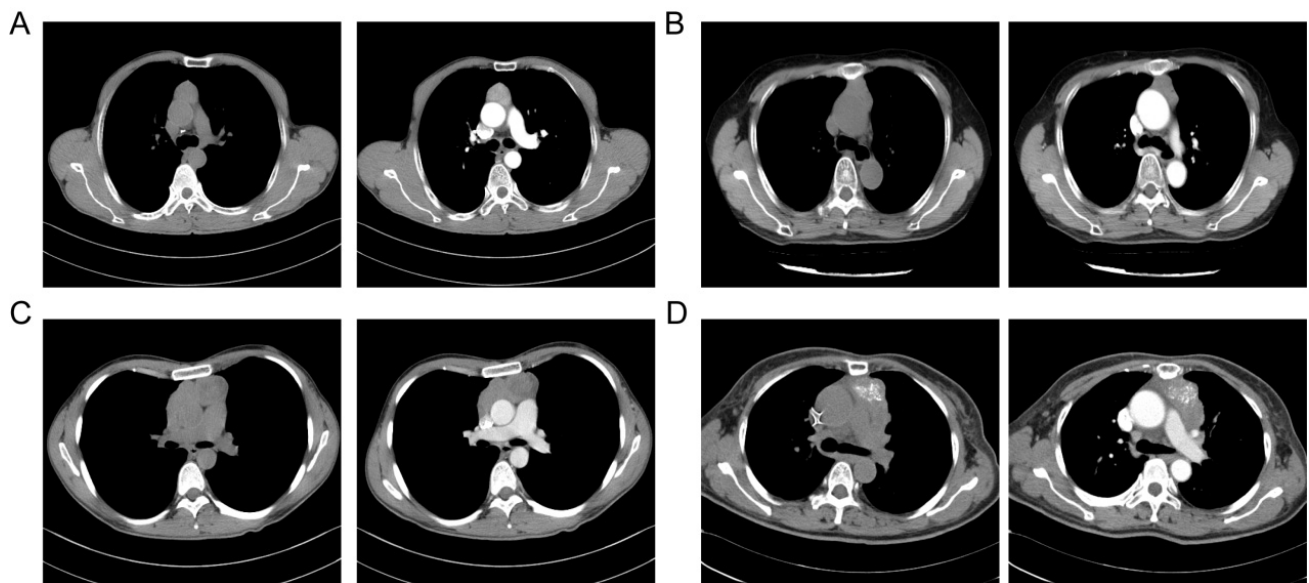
Images of computed tomography (CT). (A) Masaoka-Koga Stage I of thymoma. (B) Masaoka-Koga Stage II of thymoma. (C) Masaoka-Koga Stage III of thymoma. (D) Masaoka-Koga Stage IV of thymoma.
